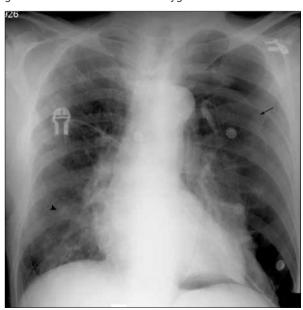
X-ray chest radiography at admission to hospital, demonstrating pneumothorax on the left side [black long arrow] and aciner opacities in the right paracardiac spaces [black arrow head]
